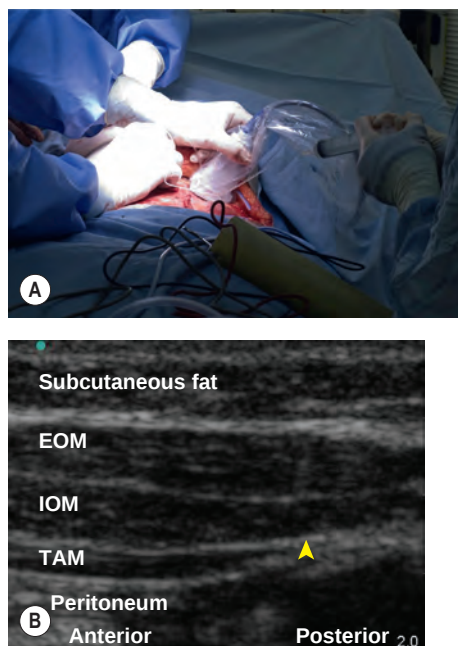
(A) Intraoperative, ultrasound-guided delivery of TAP block. Note concurrent inset of flap in background. (B) Ultrasound scan of transversus abdominis plane (TAP) block. EOM, external oblique muscle; IOM, internal oblique muscle; TAM, transversus abdominis muscle. (A, from Whebl GAC, Tan EKH. Transversus abdominis plane block in autologous breast reconstruction: a UK hospital experience. *J Plast Reconstr Aesth Surg.* 2013;66(12):1665–1670. © British Association of Plastic, Reconstructive and Aesthetic Surgeons 2013. B, from Ross AK, Bryskin RB. Regional anesthesia. In: Davis PJ, Cladis FP, Motoyama EK (eds). *Smith's Anesthesia for Infants and Children.* 2011;452–510. © Mosby 2011.)
